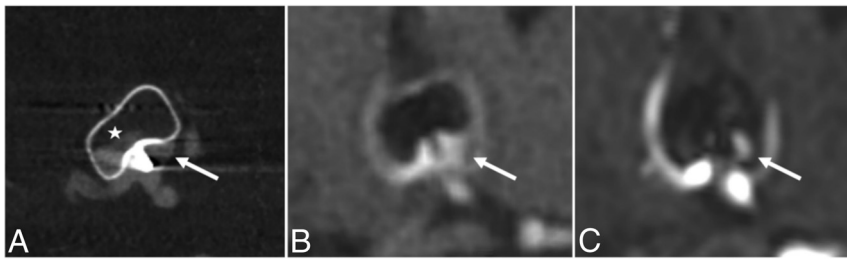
Follow-up of an incidental AcomA aneurysm treated with a WEB device. Note the deformation of the WEB excellently depicted in flat-panel detector CT (A, arrow) and UTE-MRI (B, arrow). The shape of the WEB cannot be clearly visualized using TOF-MRA after contrast administration (C, arrow). The perfusion within the WEB device, however, cannot be visualized with an MRI technique (asterisk, A) due to radiofrequency shielding effects.
